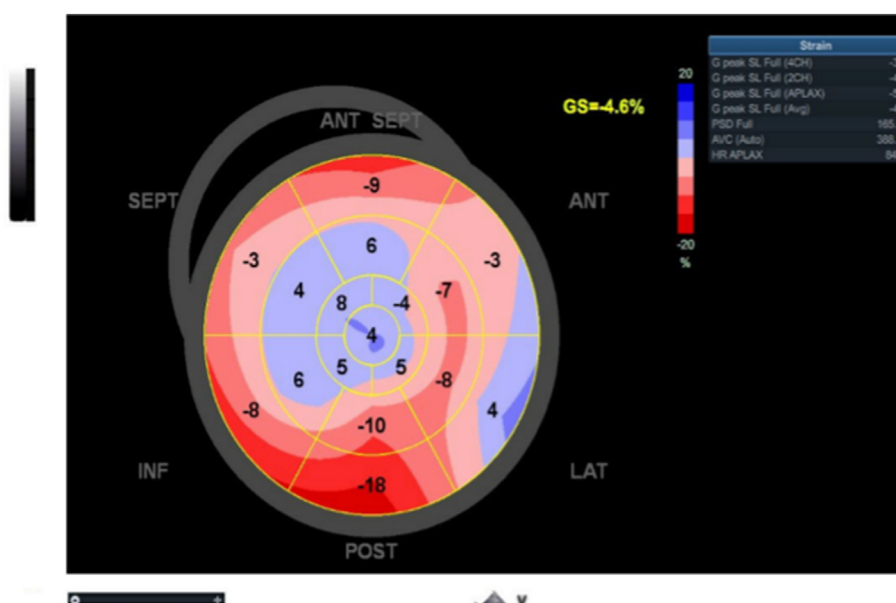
Reduced longitudinal strain - two-dimensional speckle-tracking transthoracic echocardiogram.
